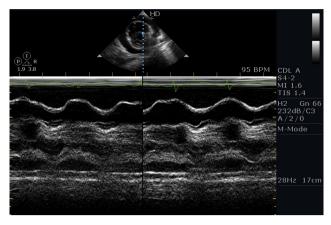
Modified parasternal long axis view showing RVOT collapse.
